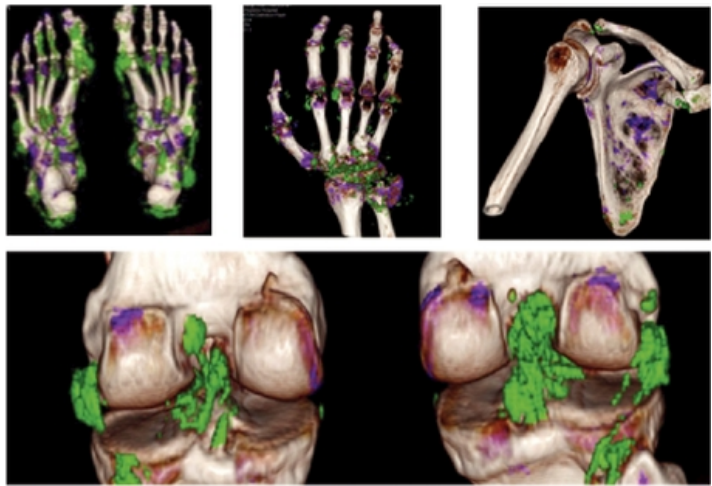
Tophi / Uric Acid Deposits (shown in green) Visualized Using Dual Energy Computed Tomography Imaging
